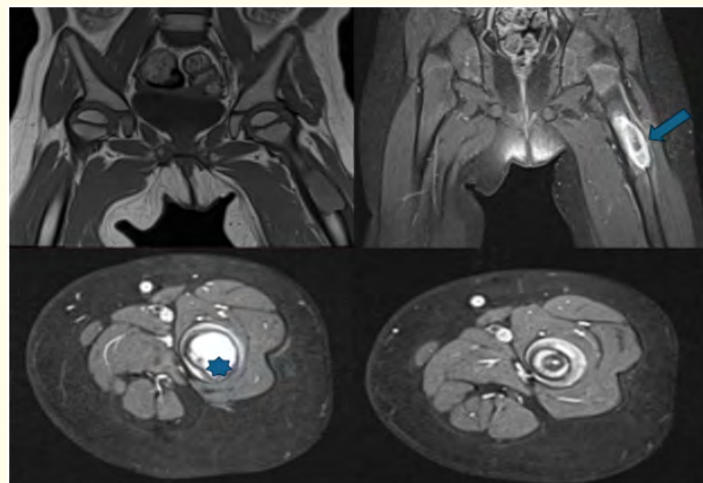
MRI of the lower limbs showing a lesion process of the upper extremity of the left femur, in T1 isosignal and T2 hypersignal (Blue arrow), enhanced after injection of gadolinium, with rupture of the cortical bone in places and infiltrating the medullary bone (Blue asterisk).
